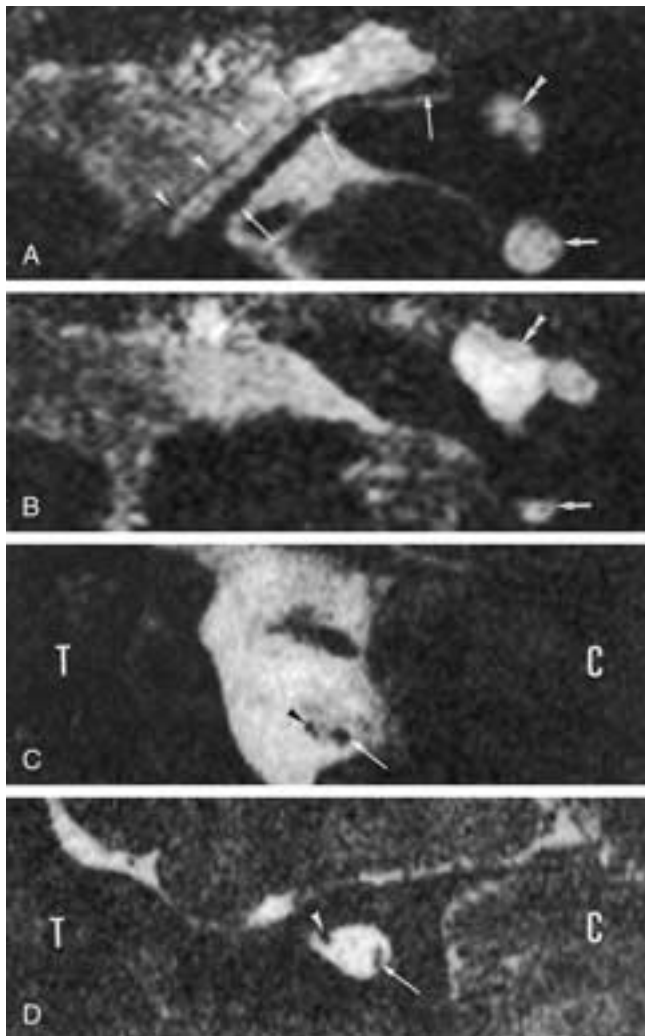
Type 2A malformation, aplasia of the cochlear branch of the VCN in the presence of an abnormal membranous labyrinth. A and B, Axial 0.7 mm thick gradient-echo T2-weighted images through the left inner ear at the level of the IAC (A) and below the level of the IAC (B). A, Fluid can be seen in an abnormal vestibule (double arrowhead) and in an enlarged posterior semicircular duct (small white arrow). The facial nerve (white arrowheads) and a common undividing VCN (long white arrows) can be followed to the fundus of the IAC and the region of the abnormal inner ear. B, The abnormal shape and enlargement of the vestibule (double arrowhead) are depicted on this image. The shape of the posterior semicircular duct is abnormal (small white arrow). C and D, Parasagittal 3DFT-CISS reconstruction perpendicular to the nerves at the level of the cerebellopontine angle (C) and IAC (D). C, Both the facial nerve (black arrowhead) and the VCN (long white arrow) can be seen in the CSF of the cerebellopontine angle. D, The facial nerve can be seen in its normal position anterior and high in the IAC (white arrowhead). The VCN, however, is not dividing into cochlear and vestibular branches and can be followed as a single nerve to the fundus of the IAC (long white arrow). C, Cerebellum; T, temporal lobe.
